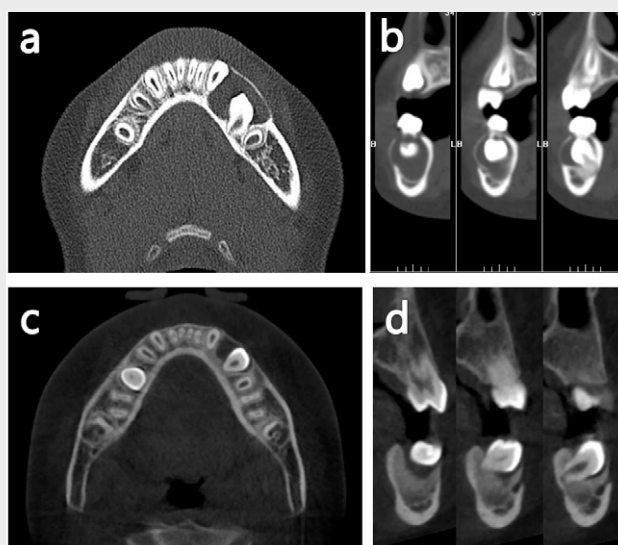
Computed tomography of case 2.
